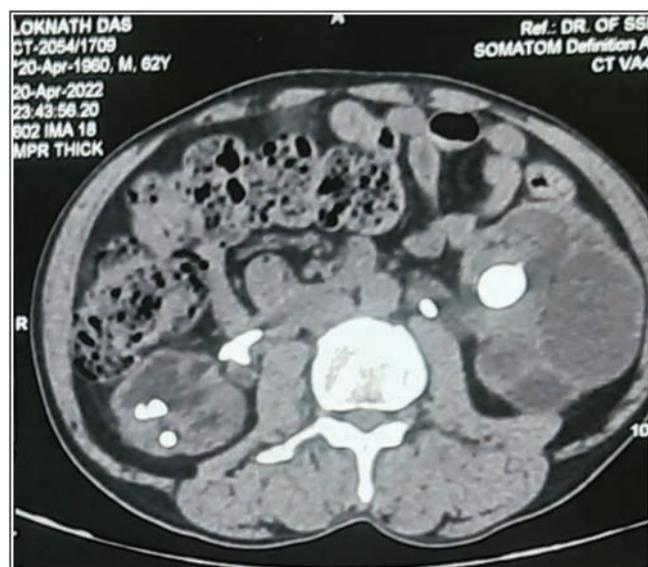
Non-contrast computed tomography report is 15 mm x 12 mm calculus in the right renal pelvis and large stag horn calculus of size 33 mm x 32 mm (Hounsfield unit+1440) in the left renal pelvis and thinning of cortex with bilateral hydronephrosis
